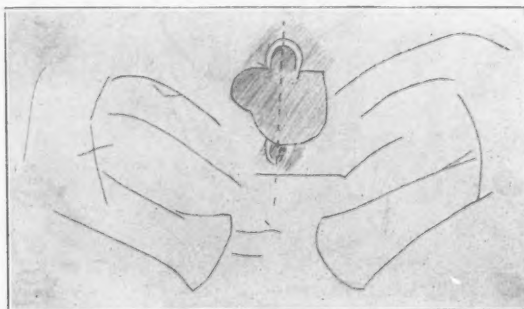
Tracing of an X-ray of a pouch of the esophagus. The dotted line is drawn through the tips of the spinous processes. Notice the asymmetry of the pouch. Reduced one-half.
